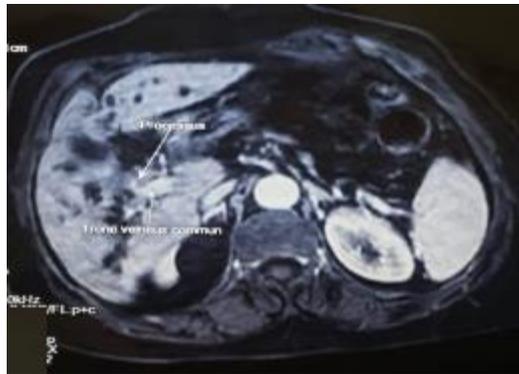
MRI appearance suggestive of perihilar cholangiocarcinoma
